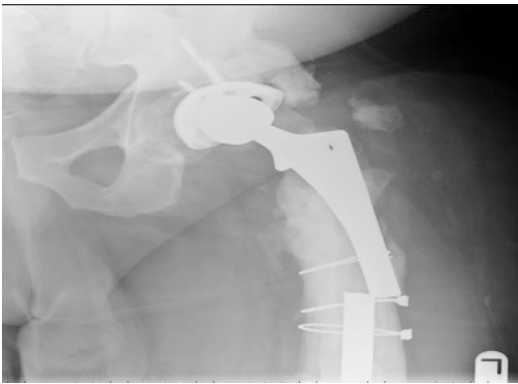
AP and lateral radiographs of the left hip demonstrating a broken fully porous-coated femoral component. The mechanism of failure is due to lack of proximal femoral support leading to cantilever bending and fatigue fracture
